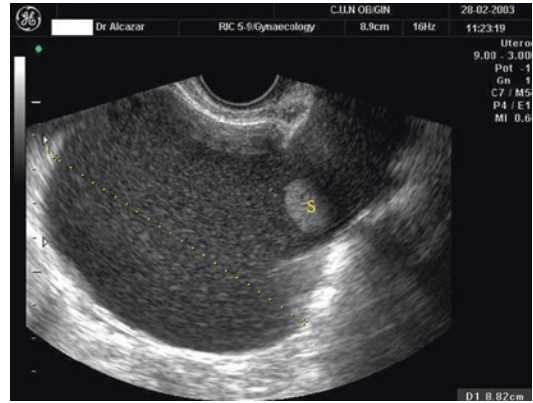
Transvaginal ultrasound showing an atypical endometrioma containing a solid area (S) arising from internal surface of cyst’s wall
